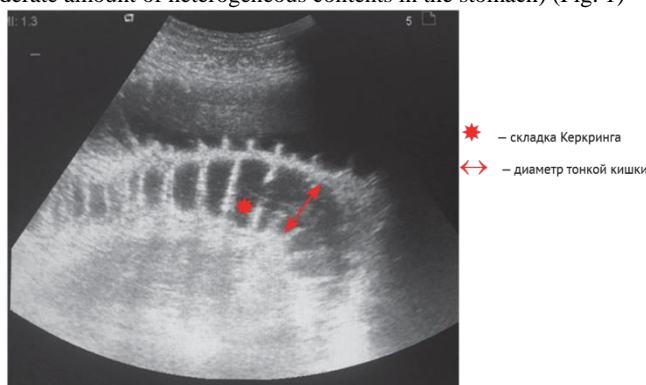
Ultrasonogram of the abdominal cavity of patient G. Conclusion: signs of small bowel obstruction
